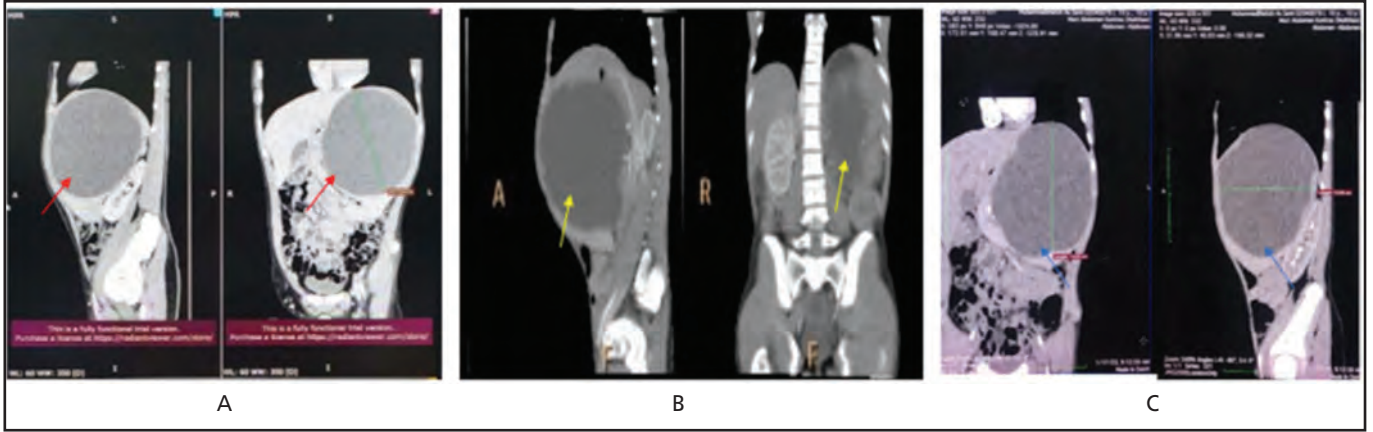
Abdominal CT scan of case 1, showed splenomegaly with cystic lesion suggested splenic epidermoid cyst with calcification on the wall (A). On abdominal CT scan of case 2, indicated splenic cyst that could be an epidermoid cyst, splenic abscess, lymphangioma or pseudocyst with enlargement to caudomedial (B). On case 3, the cystic mass showed in CT scan exerting pressure on the stomach, duodenum and pancreas (C)
